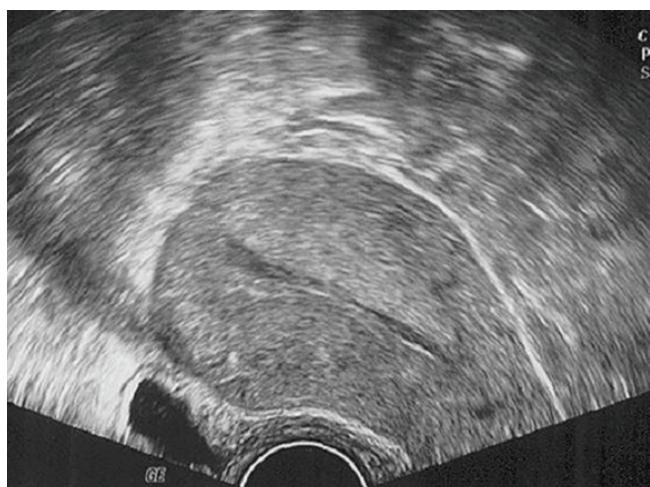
Transvaginal sonogram 4 weeks after operation showed a thin linear endometrial cavity and no remnant placental tissue.
